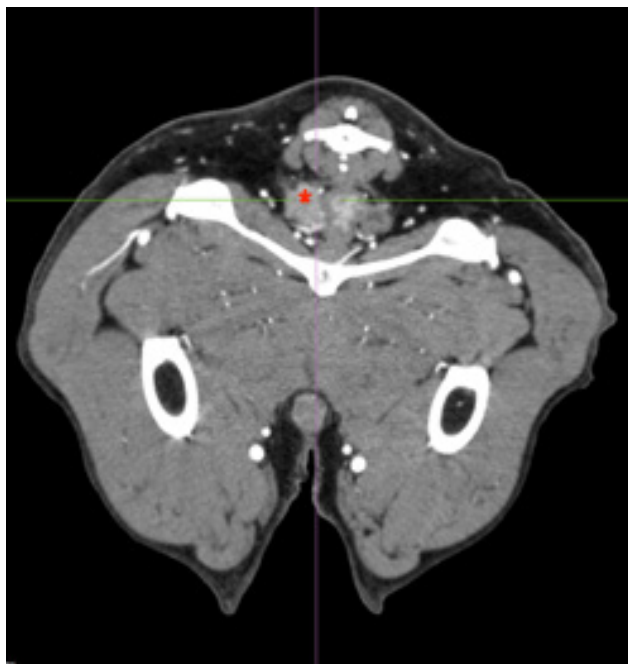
Transverse computed tomography projection demonstrating heterogeneous, contrast-enhancing anal gland sac mass (red star)
